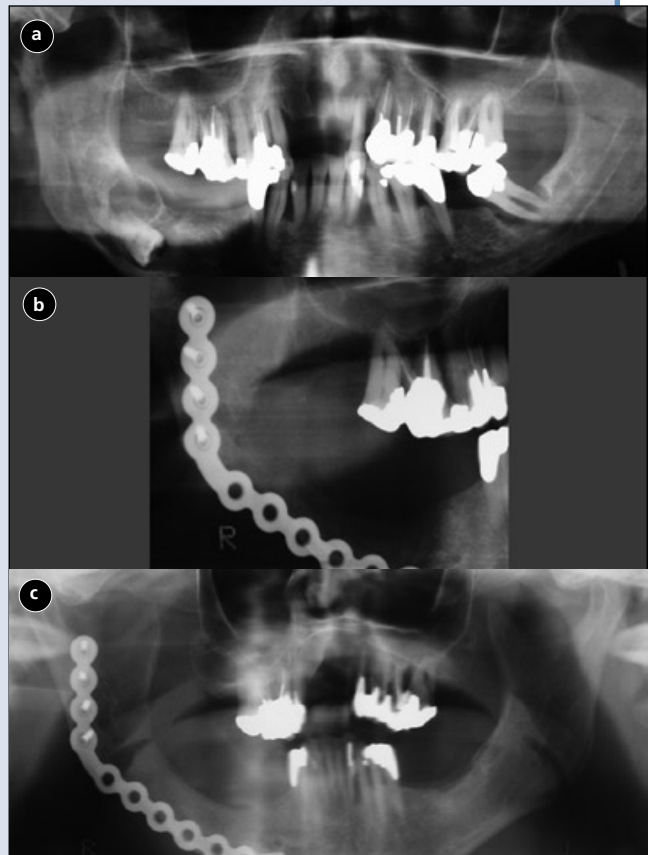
(a) Panoramic radiograph of a 62-year-old man demonstrating an impacted tooth 48 with an associated multi-locular, radiolucent lesion (ameloblastoma). (b) Panoramic radiograph 9 months following mandibular resection and reconstruction with a BMP bioimplant shows limited evidence of bone formation. (c) One year following reconstruction of the mandibular defect, this panorex revealed complete regeneration of the mandible.
